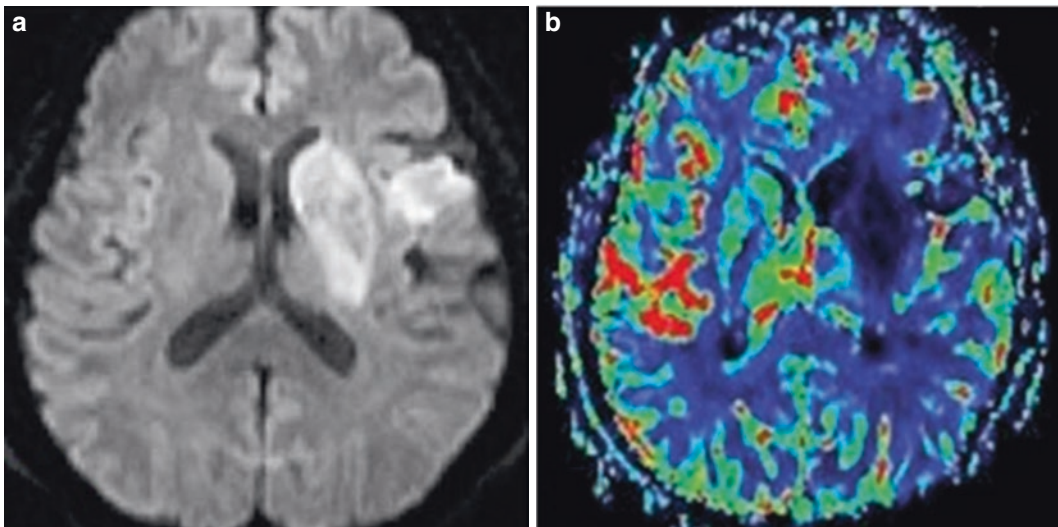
Acute cerebral infarction of the left basal ganglia and left temporal lobe. A 62-year-old male patient who presented with weakness in his right limbs for 3 h. Transverse DWI shows acute cerebral infarction of the left basal ganglia and left temporal lobe (a). Transverse PWI
